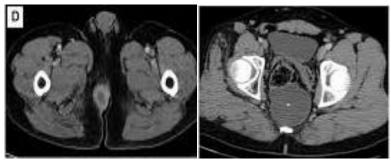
CT-scan of pelvic show abscess and fistulae
